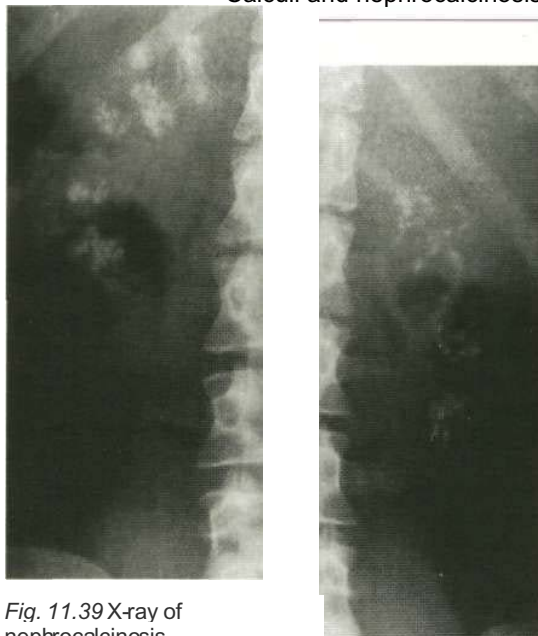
X-ray of nephrocalcinosis.
